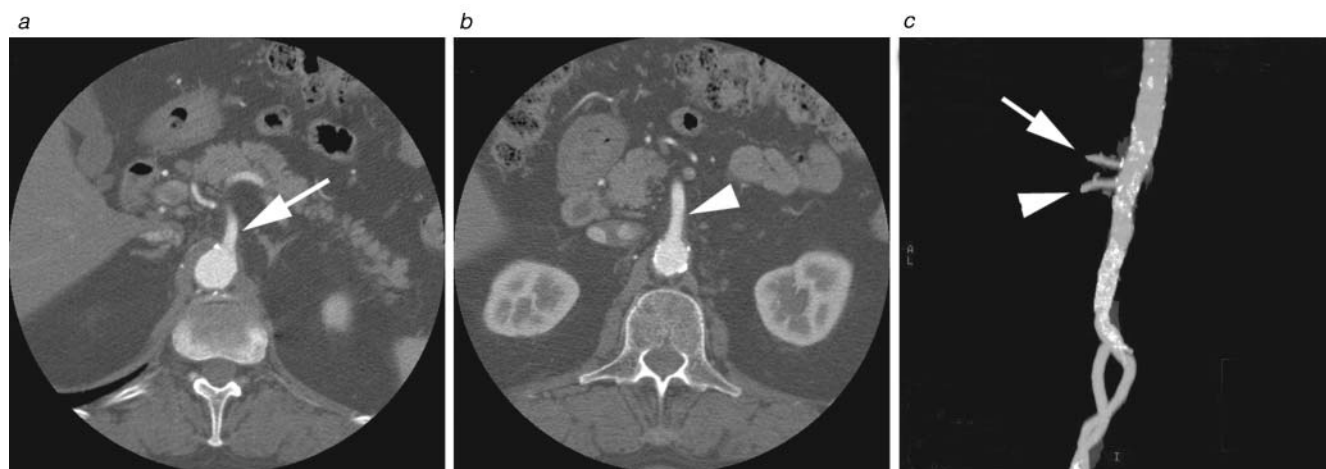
Shown are computed tomography scans of mesenteric vessels: (a) transaxial image of celiac artery (arrow); (b) transaxial image of the superior mesenteric artery (SMA) (arrowhead); and (c) three-dimensional reconstruction of aorta and origins of celiac artery (arrow) and SMA (arrowhead).
